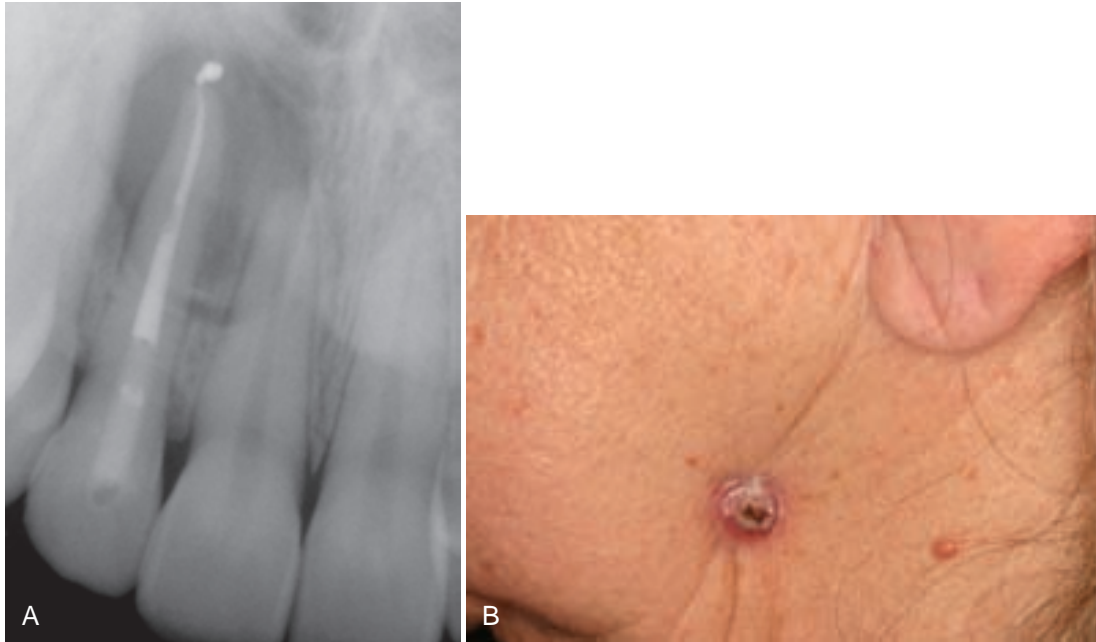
A, Periapical actinomycosis manifesting within an apical radicular cyst after root canal therapy. B, Actinomycosis from a carious mandibular molar resulting in cutaneous sinus tract. (A, Courtesy of Dr. Michael Joseph, private practice, Worcester, Mass.)
